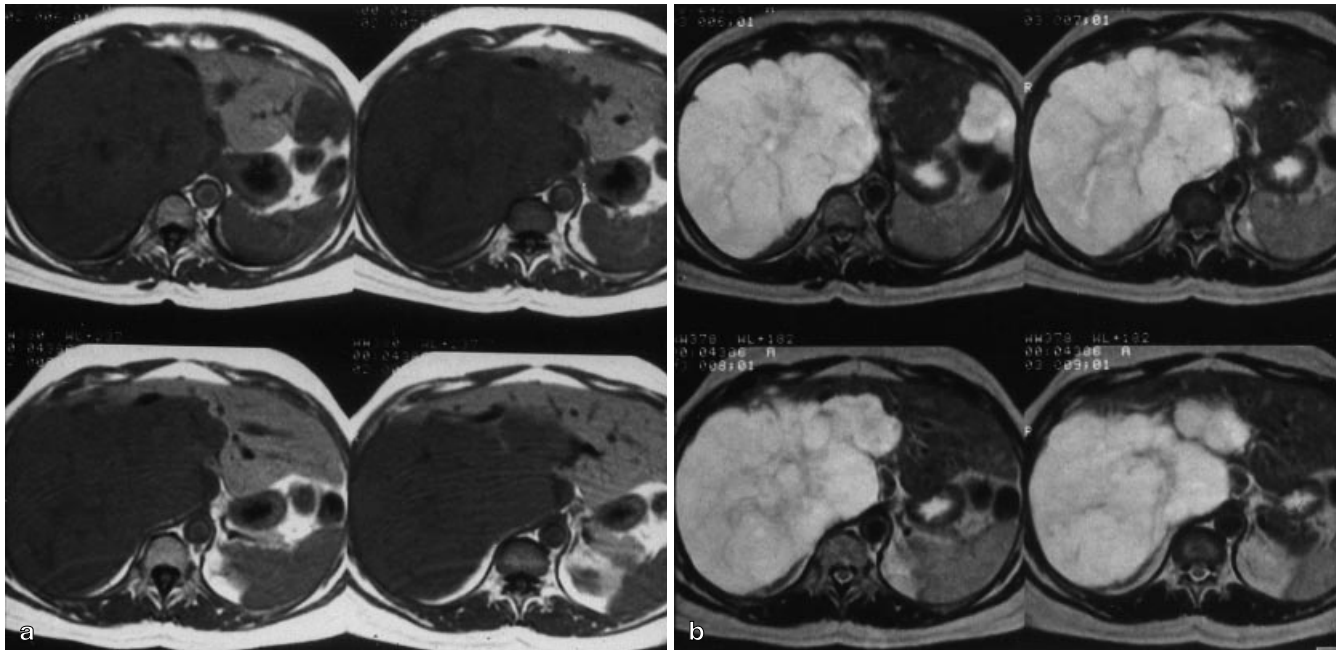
Giant hemangioma. a On T1-weighted images the lesions appear definitely hypointense, whereas it is markedly bright on b T2-weighted images. Internal areas of fibrosis are detected as low-intensity bands both on T1- and T2-weighted images
